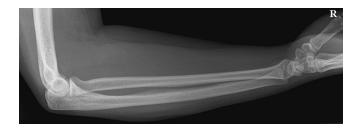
Example of a lateral forearm radiograph.
